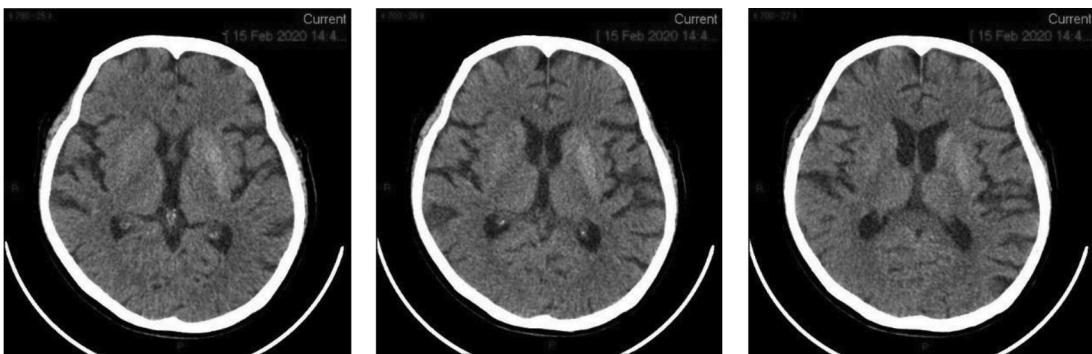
A-C Non-contrast CT scan at presentation with choreoathetosis, 6 weeks from the first presentation
